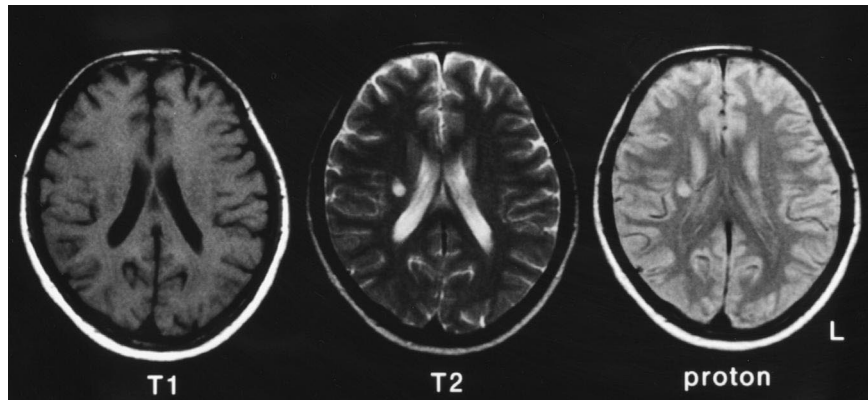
Magnetic resonance imaging of the head in a patient with asymptomatic cerebral thrombosis.
